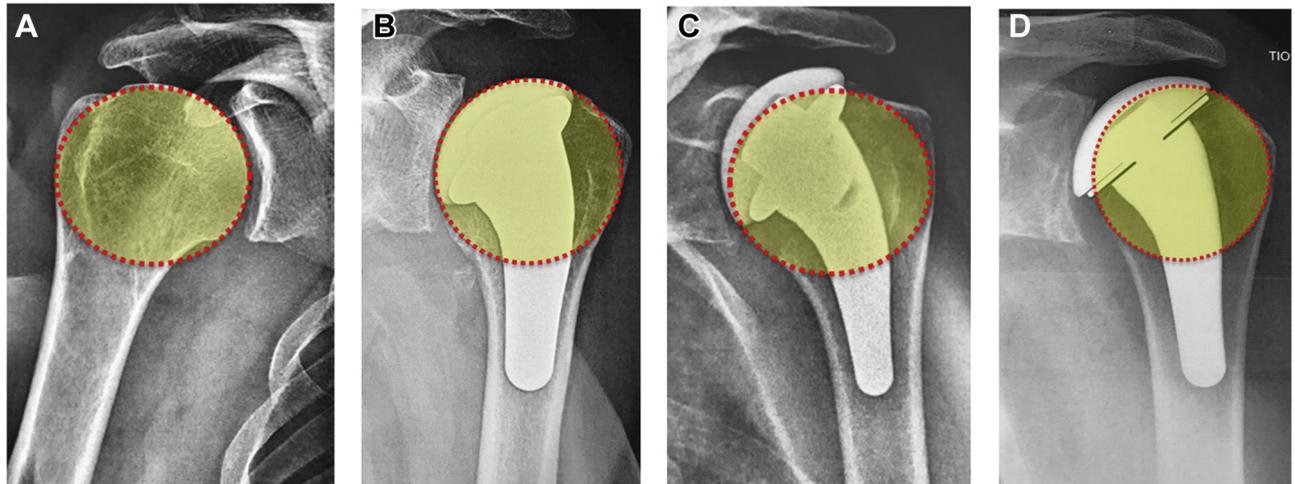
Evaluation of humeral reconstruction quality using circle method according to Mears et al.²⁵ (A) Native humerus. (B) Postoperative radiograph showing anatomic humeral reconstruction. (C) Postoperative radiograph showing nonanatomic humeral reconstruction because of proud prosthesis. (D) Postoperative radiograph showing nonanatomic humeral reconstruction because of oversized prosthetic head.
